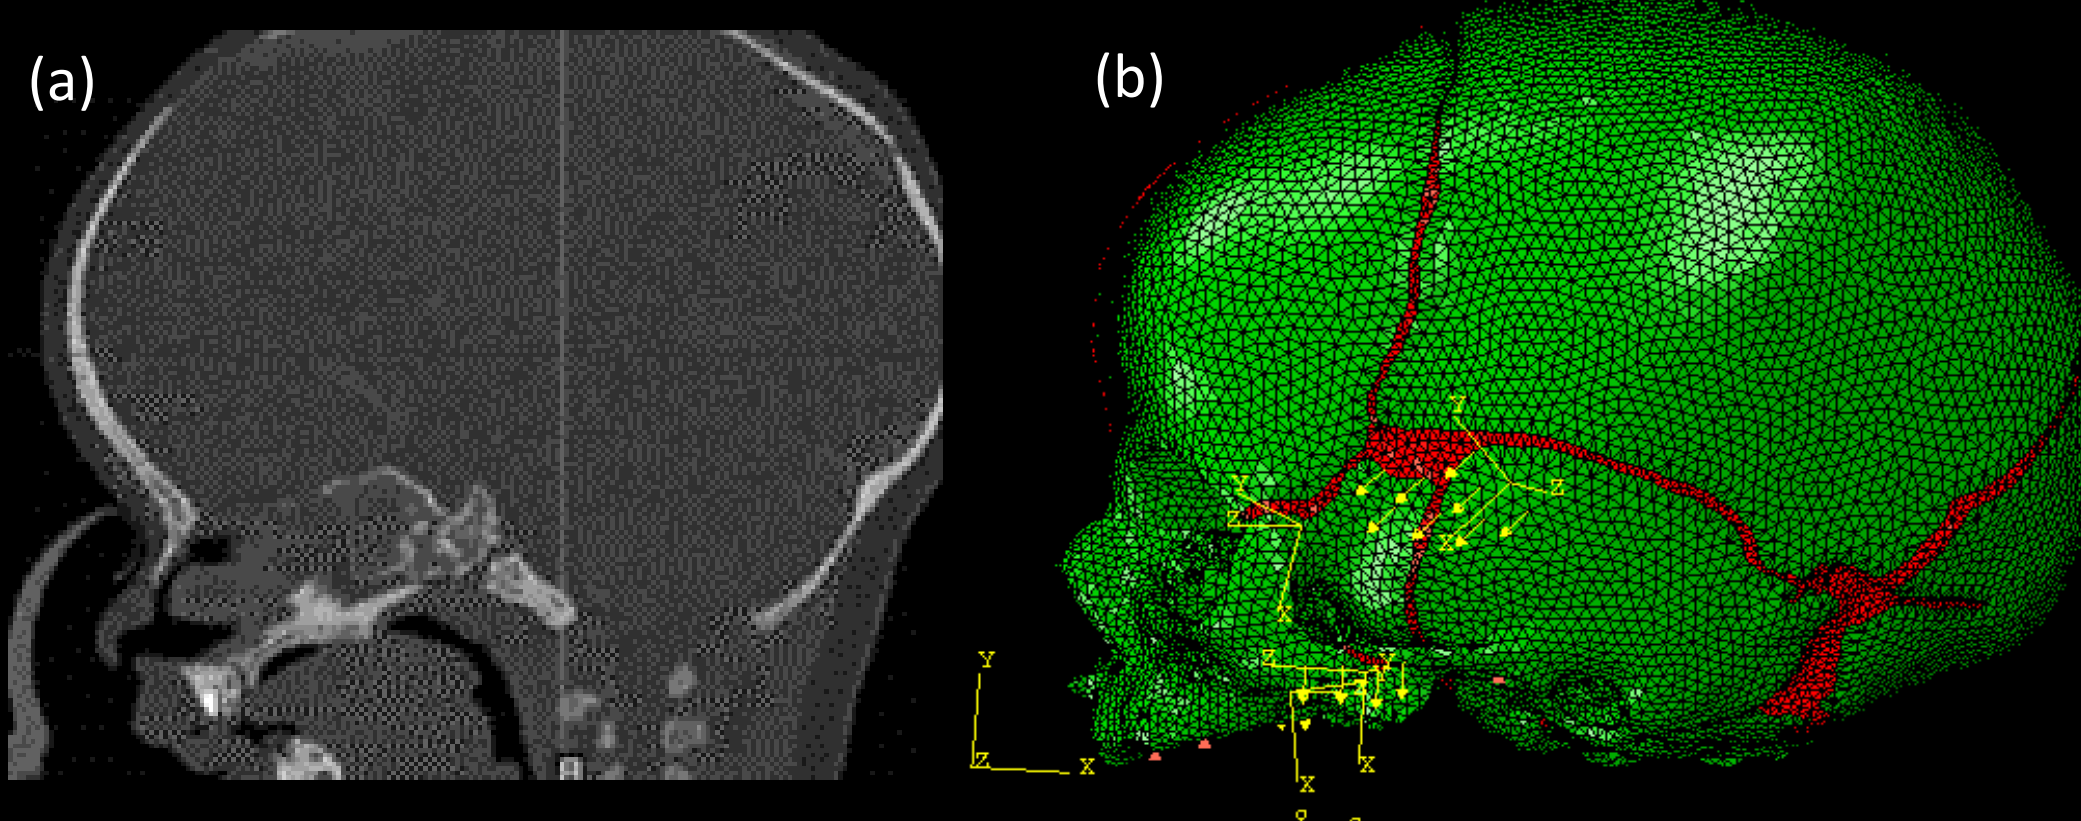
(a) CT sagittal section of an infant skull; (b) 3D FE model with bone (green), cranial sutures (red) and internal ICV (unseen) materials. Mechanical loads for the temporalis and masseter are shown as arrows.
